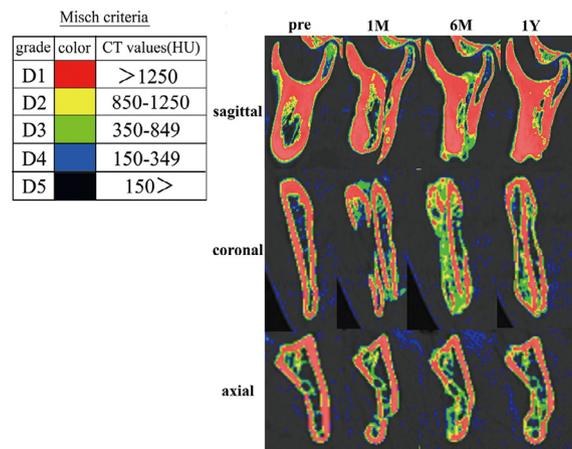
Classification of 5 color grades. (A) On the basis of the Misch criteria, the color grades were classified into 5 steps using the CT values. (B) The color grades of the cleavage between bone fragments increased from D5 to D1 over time.
